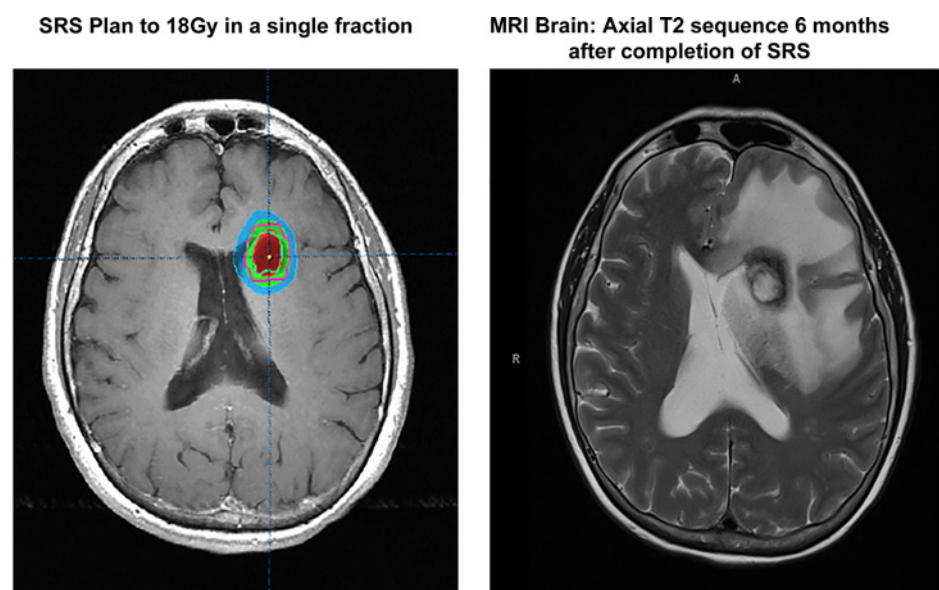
Left, SRS plan; right, MRI imaging, axial T2 Sequence representing CSRN.
